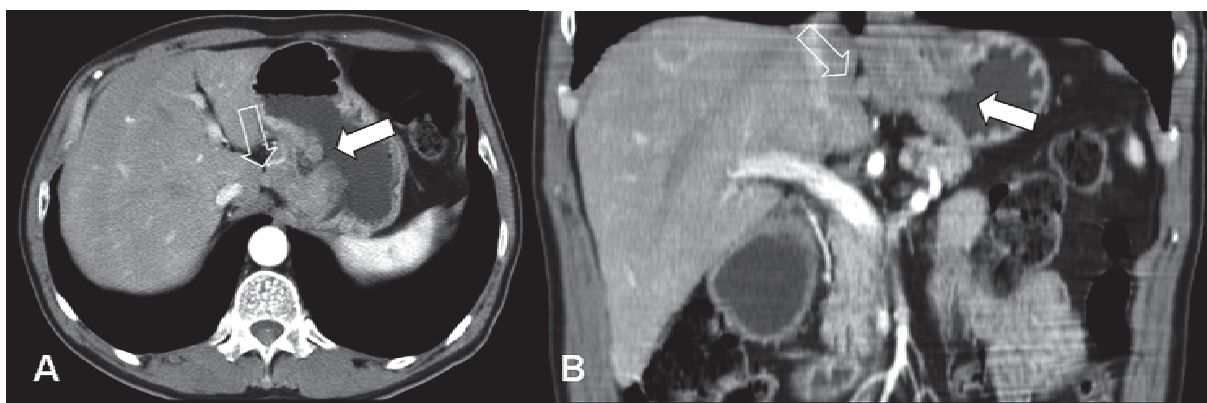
A. CT Transverse Scan. B. CT Coronal Reconstruction. Gastric carcinoma causes an irregular wall thickening on the proximal tract of the stomach (arrows). Peri-gastric suspected lymph nodes are associated (empty arrows).
